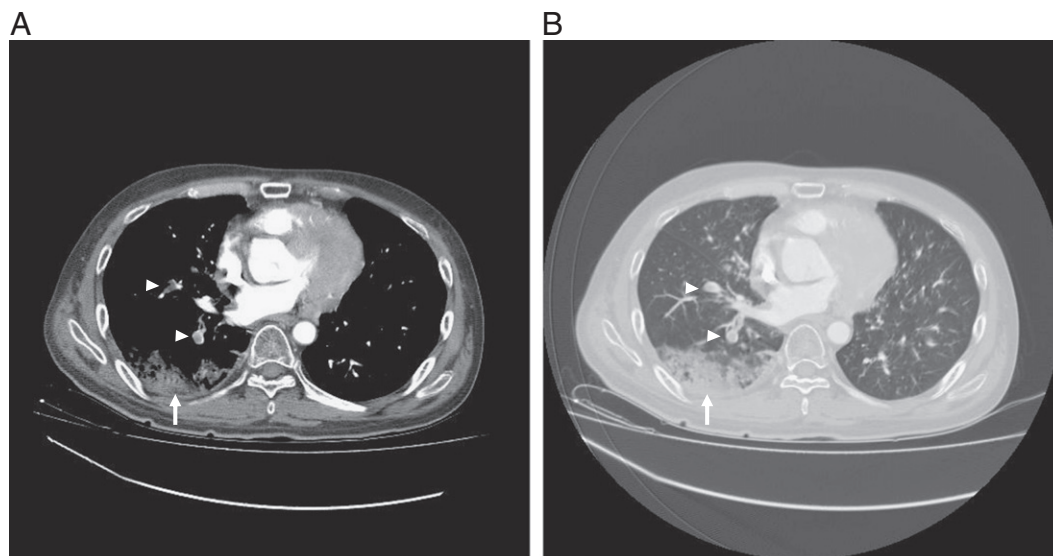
Chest CT (1A, mediastinal window; and 1B, lung window) shows that pulmonary emboli (arrow heads) are located in the segmental and subsegmental pulmonary arteries as sharply delineated arterial filling defects in consecutive image sections. Pulmonary infarction (arrows) is identified as a wedge-shaped peripheral consolidation in the territory of a segmental embolus.
